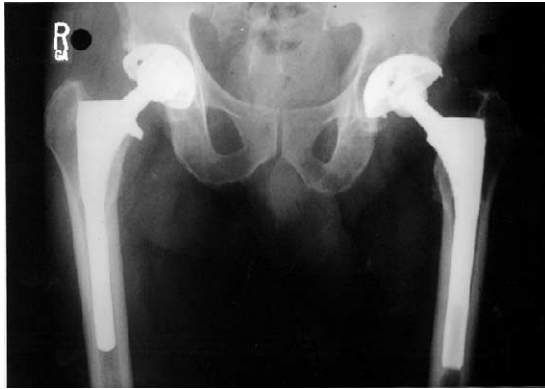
Case 1. Anteroposterior pelvis radiograph with left hip revision 6 years postoperative and 1 year postoperative primary right total hip arthroplasty with a noncemented Anatomic Porous Replacement stem and noncemented Converge acetabular cup and a 28-mm Metasul head and liner.
